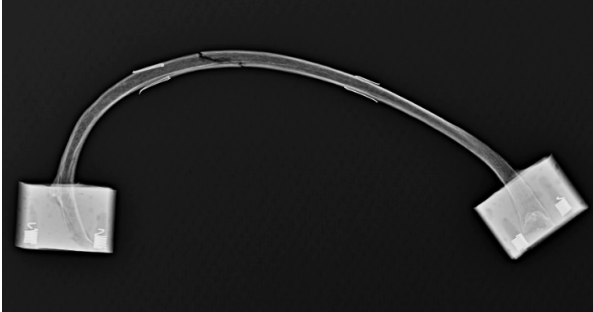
Pair 14 rib (left) and rib+CC (right) post-test x-rays (not to scale)
